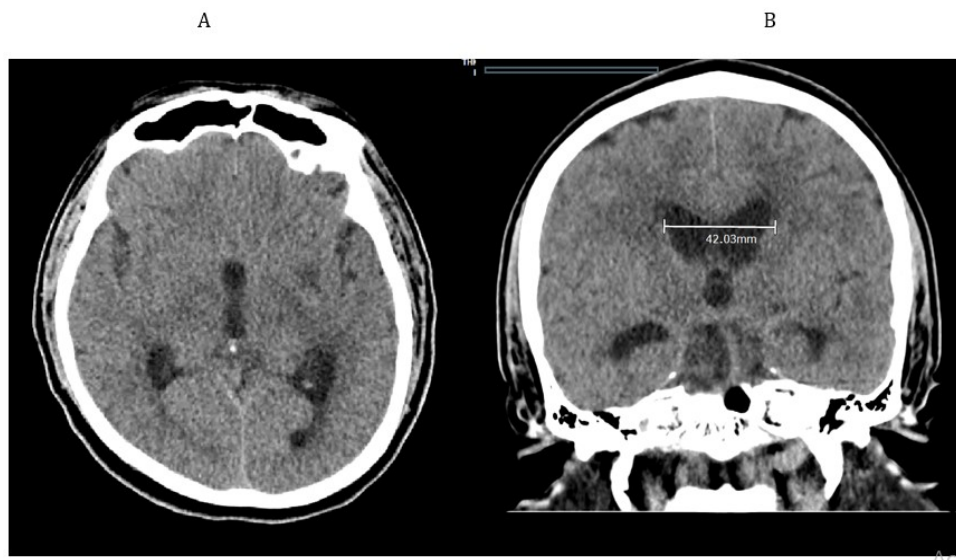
A and B: (1). Stable mild communicating hydrocephalus compared to prior CT, we see mild dilatation of lateral ventricles along with mild dilatation of peri-ventricular area head on 1/25/21 (2). Stable area of low attenuation within left lower basal ganglia, which likely represents a perivascular space versus chronic ischemic white matter lesion.
